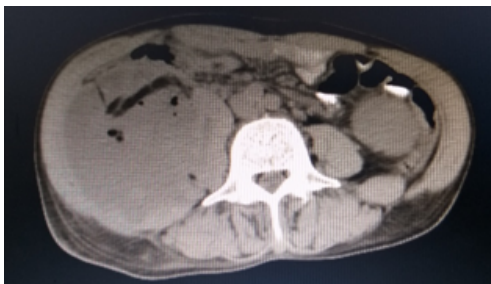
Computerised Tomography (CT)
